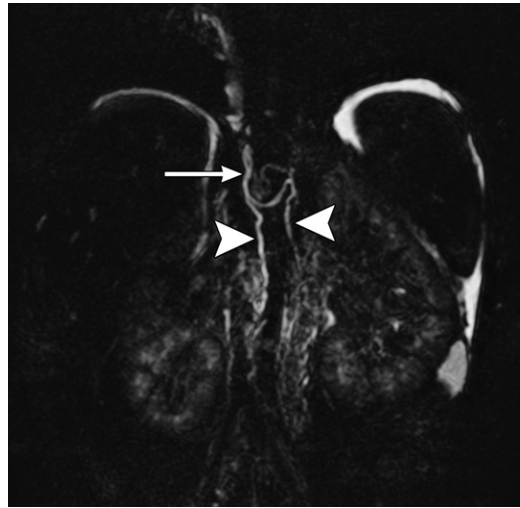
Knotted appearance of lymphatic channels. (a) Image from conventional intranodal lymphangiography with ethiodized oil in a 12-year-old girl with a renal transplant demonstrates a knotted appearance (arrow) of lymphatic channels relating to valves. (b) Coronal T2-weighted MR image in a 17-year-old adolescent boy with nonspecific abdominal pain demonstrates a similarly knotted appearance (arrows) of a normal thoracic duct.
